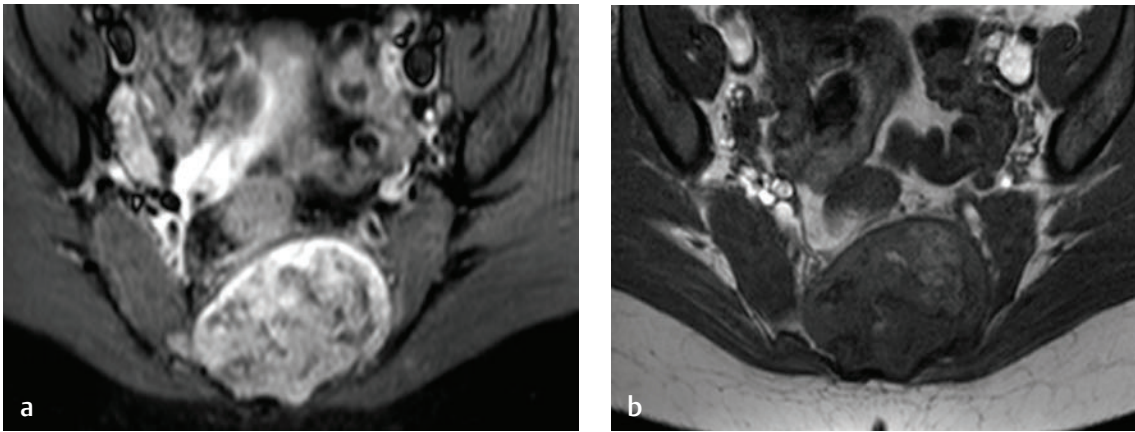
This (a) axial fat-suppressed T2-weighted image of a sacral chordoma reveals a hyperintense lesion that has extended into the pelvis and left gluteal muscles. (b) The lesion appears mostly hypointense with focal regions of hyperintensity, likely representing hemorrhage or mucinous material on an axial T1-weighted image.
